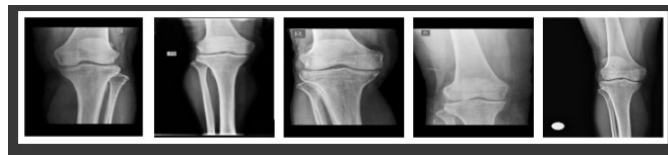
Knee Osteoporosis X-Ray images sample
